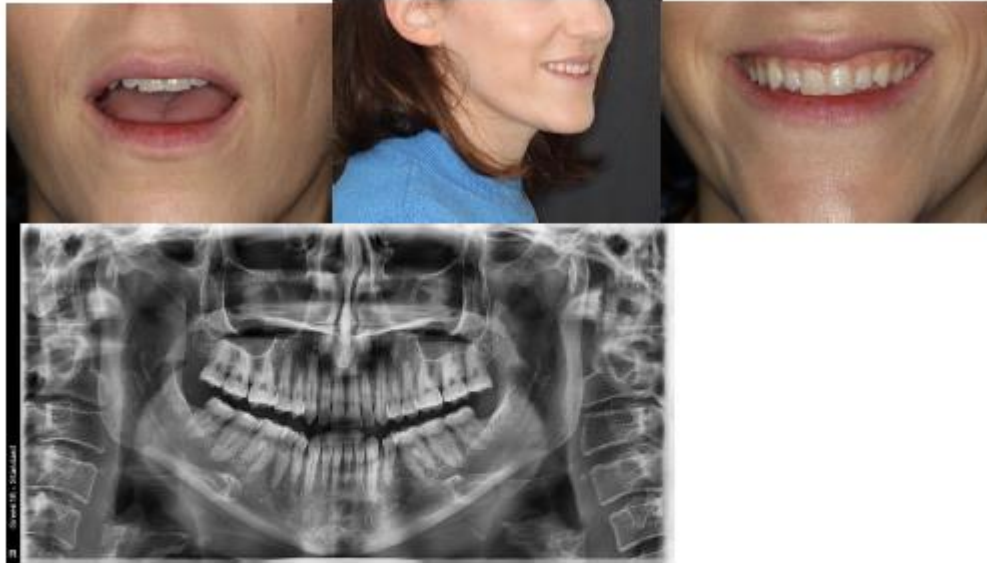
Final extra- and intraoral situation after treatment with in-office direct Graphy aligners. The treatment was performed with longer straight aligner margins, but without any attachment on the teeth for additional anchorage. The final orthopantomogram shows no pathologies.
